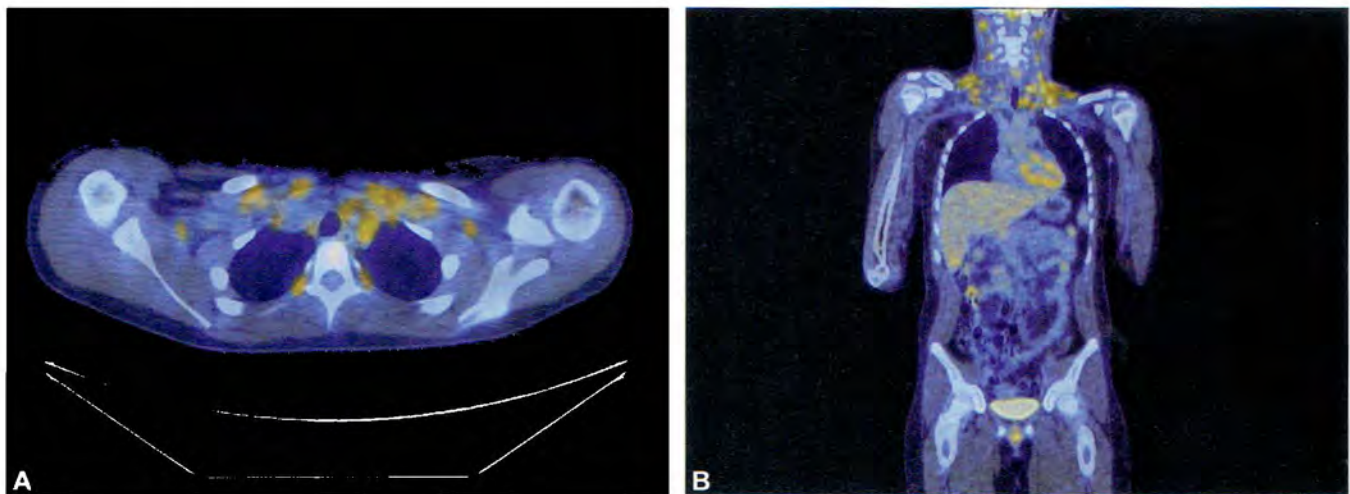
Following two cycles of chemotherapy, dramatic improvement in size and FDG activity of the persistent primary mass is demonstrated on follow-up positron emission tomography/computed tomography (PET CT) imaging.
